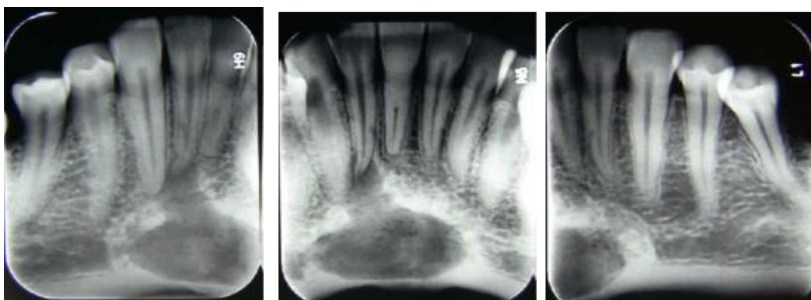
Periapical radiographs representing a well-defined radiolucent lesion
